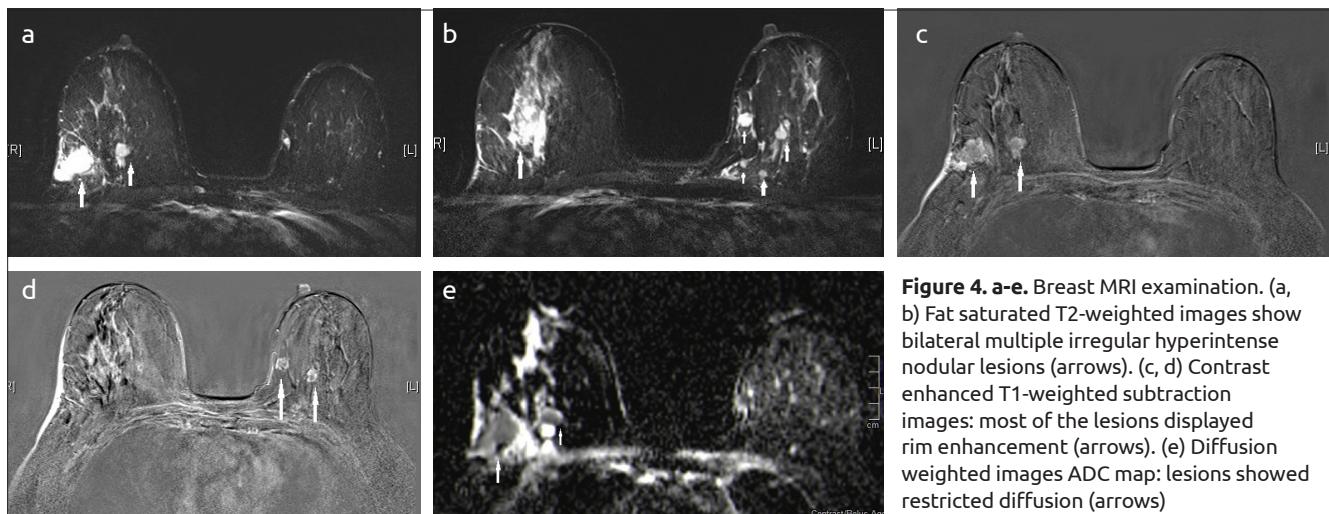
a-e. Breast MRI examination. (a, b) Fat saturated T2-weighted images show bilateral multiple irregular hyperintense nodular lesions (arrows). (c, d) Contrast enhanced T1-weighted subtraction images: most of the lesions displayed rim enhancement (arrows). (e) Diffusion weighted images ADC map: lesions showed restricted diffusion (arrows)
